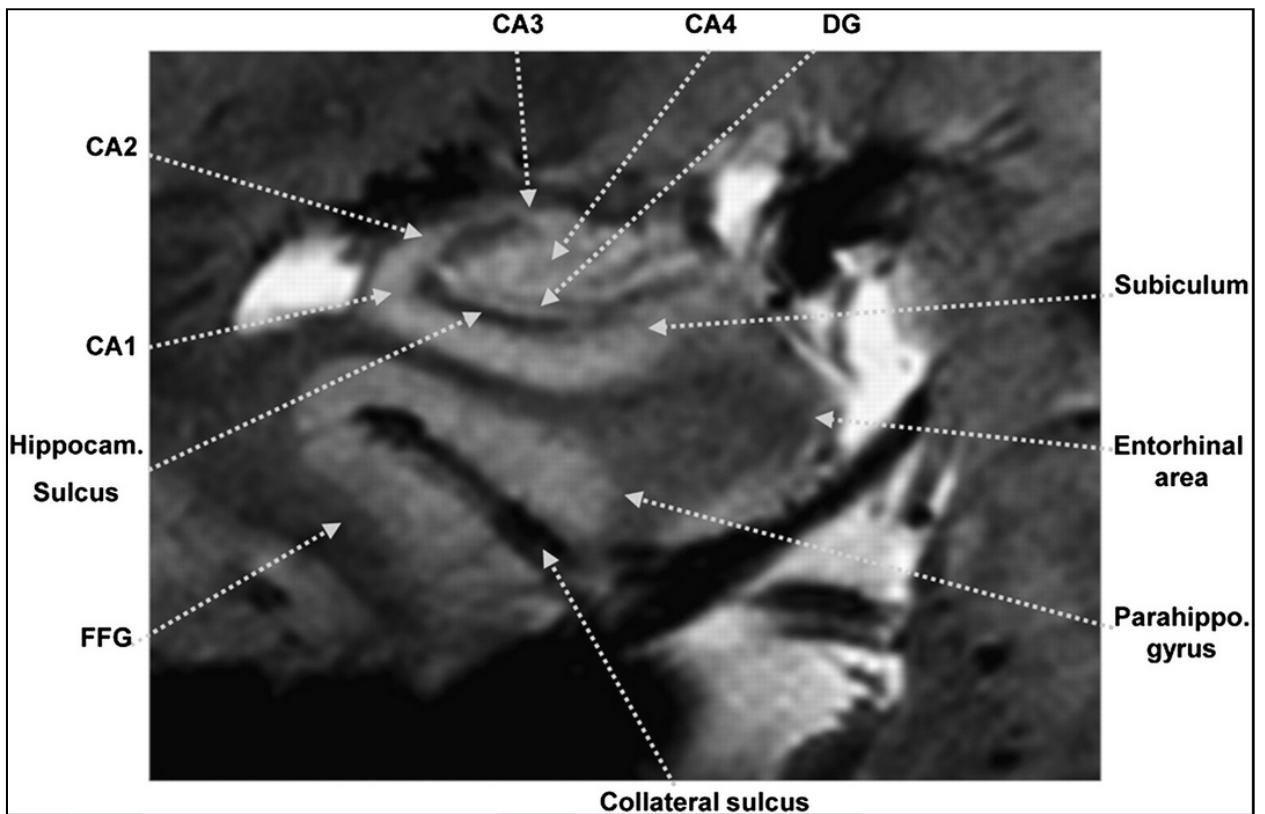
Coronal 7.0-T MR image of hippocampus. Hippocampal substructures such as CA1, CA2, subiculum, and CA4/DG are clearly visible. FFG = fusiform gyrus [Source: Cho et al., 2010. Substructural Hippocampal Glucose Metabolism Observed on PET/MRI. *J Nucl Med.* 2010;51:1545-1548.]
